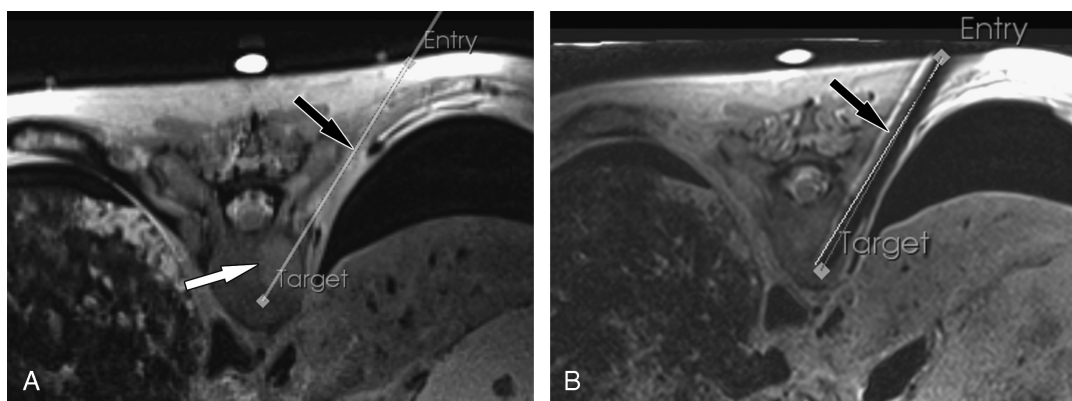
Image overlay navigated MR-guided biopsy of an osseous lesion of the eighth thoracic vertebral body: A, Axial T2-weighted MR image demonstrates the planned biopsy path (black arrow) through an osseous lesion in the eighth thoracic vertebral body (white arrow). B, Axial intermediate-weighted turbo spin echo MR image after the drill placement demonstrates the tip of the drill (black arrow) through the target lesions. Postprocedural assessment of the target error using the PerkStation module of the 3D Slicer software shows the planned biopsy path (thick line) and the actual biopsy path (thin line). The target error was 4.3 mm.
